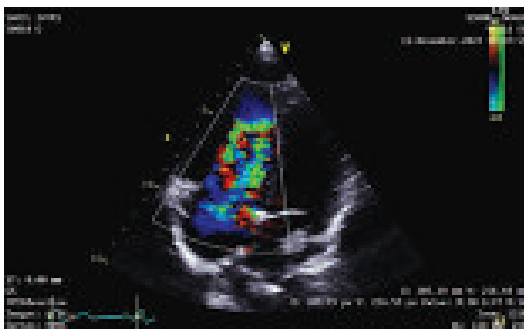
TTE 2D guided Color Doppler; A4C view showing moderate TR
